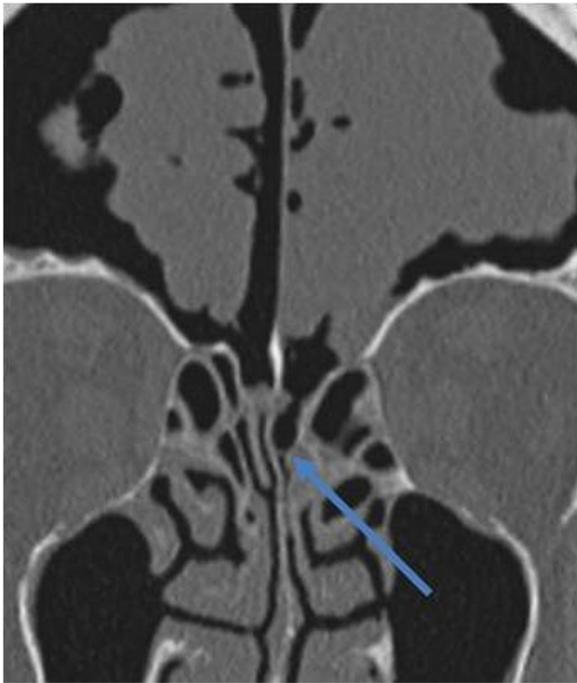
Unenhanced head computed tomographic image of the head, coronal plane. A massive pneumocephalus is present in the subdural space. An interruption in the cribriform plate is also present (arrow), in exactly the same place as the anatomical variant.
